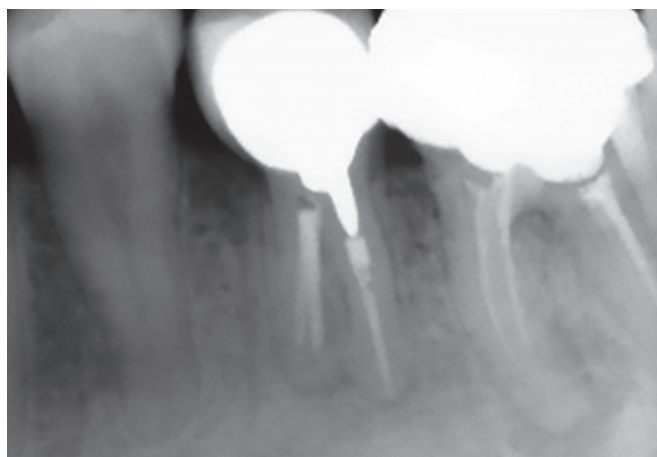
Radiograph after post placement on #35
